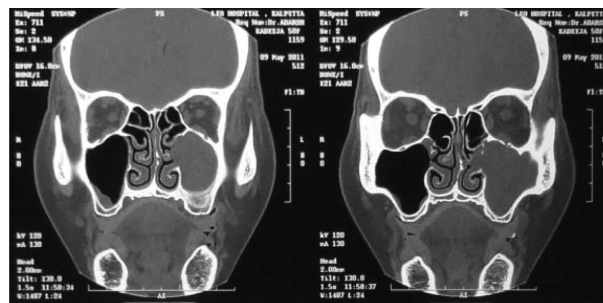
CT Paranasal sinus
